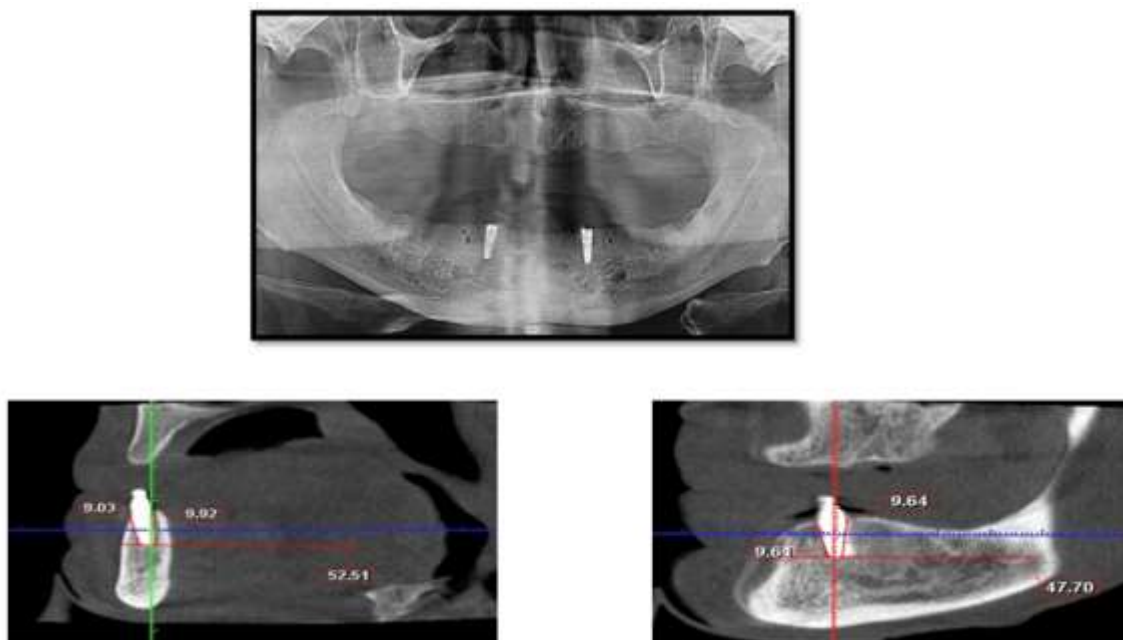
CBCT used to assess marginal bone changes
